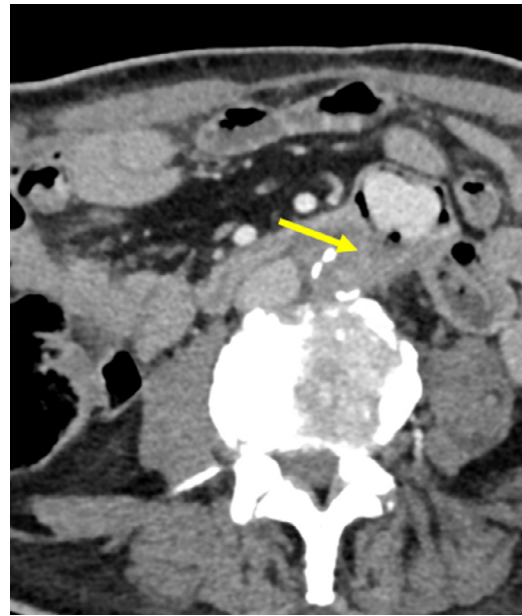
CT-scan with intravenous injection of contrast medium showing the fluid and gas (yellow arrow) surrounding the aortic prosthesis.
